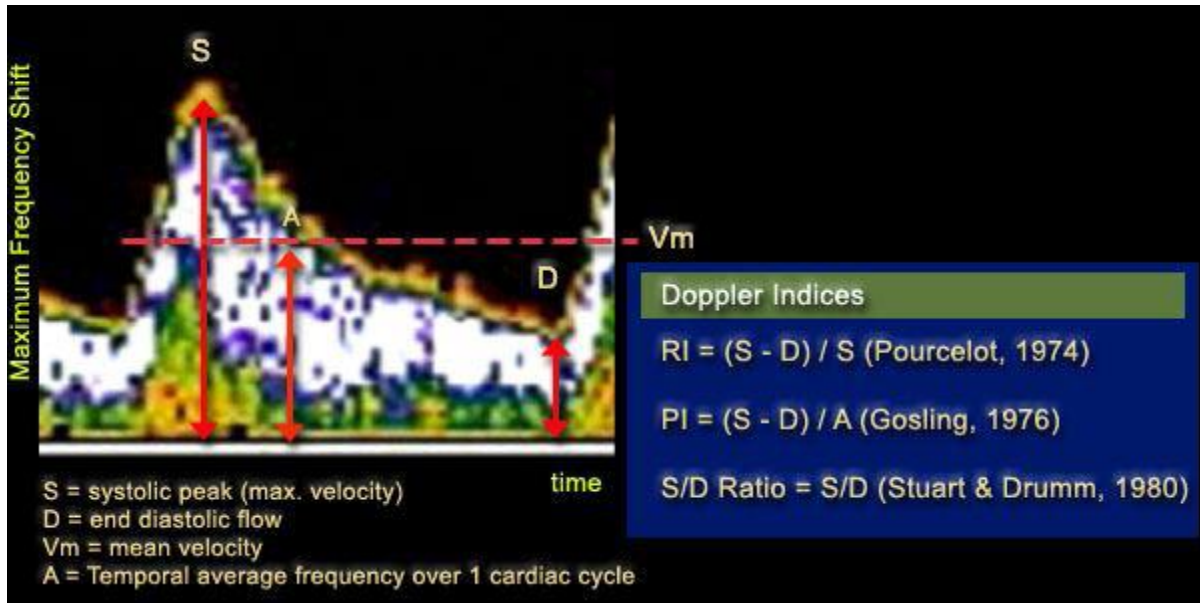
Commonly used umbilical artery Doppler Indices and their calculation.
